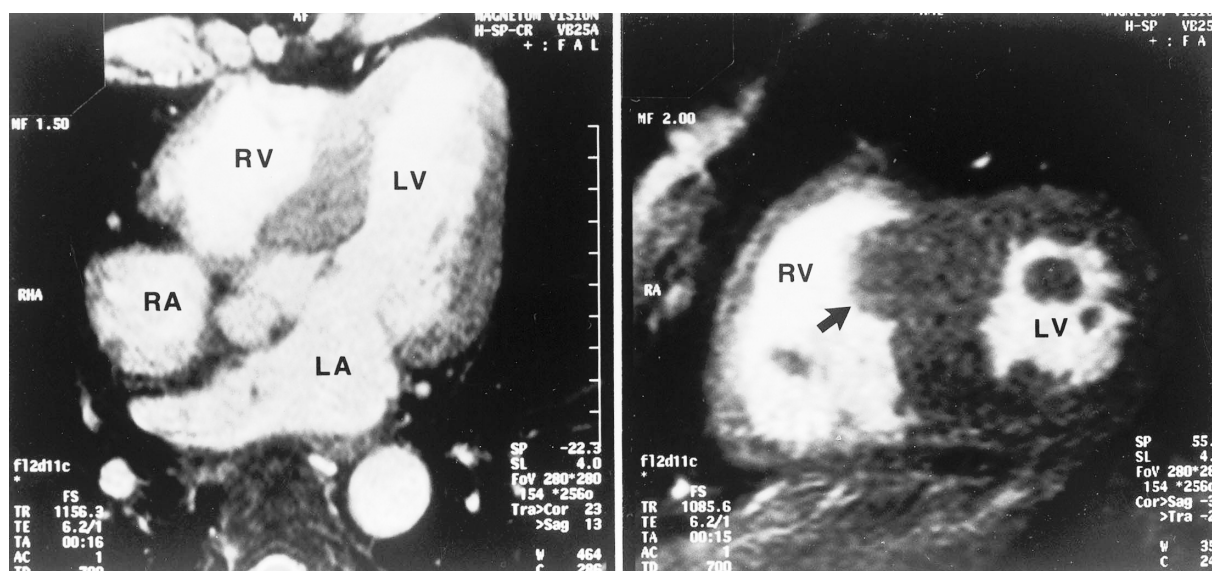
Magnetic resonance image showing ventricular hypertrophy with asymmetrical septal hypertrophy
